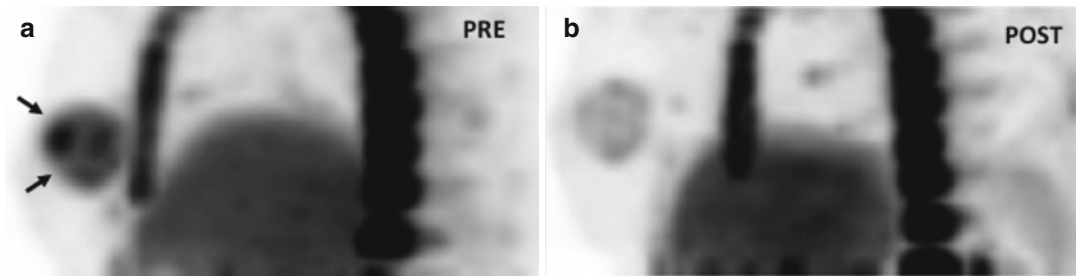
FLT-PET in a patient with HER-2-positive locally advanced breast cancer treated with chemotherapy and anti-EGFR agent. Pre-therapy (a). Sagittal FLT-PET image shows an increased uptake in the breast (*arrows*) corresponding to tumor involvement. SUV max = 5.6.
